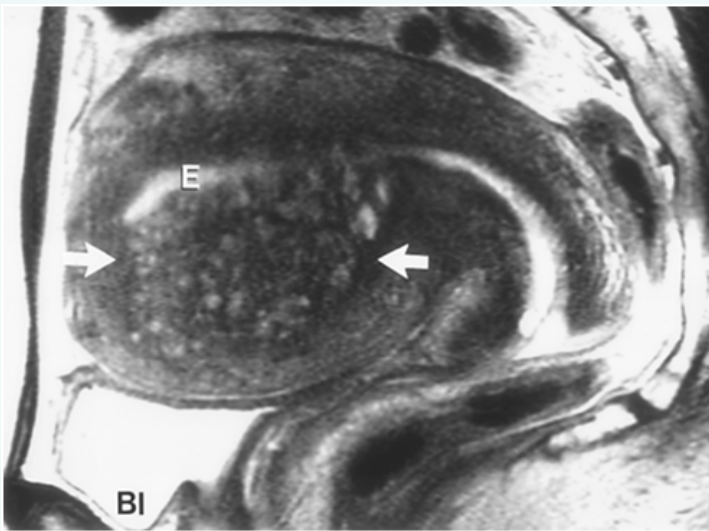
focal adenomyosis of the anterior wall with large adenomyoma within the myometrium (arrows). This is the same patient as in figure 2. From RadioGraphics, 19, S147-S160.
